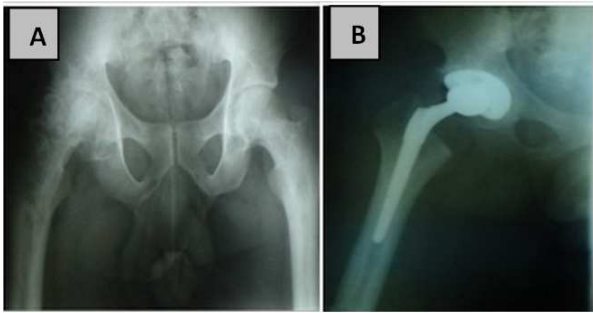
A 35-year-old man with right hip osteoarthritis B X-ray after THA with non-cemented components.
